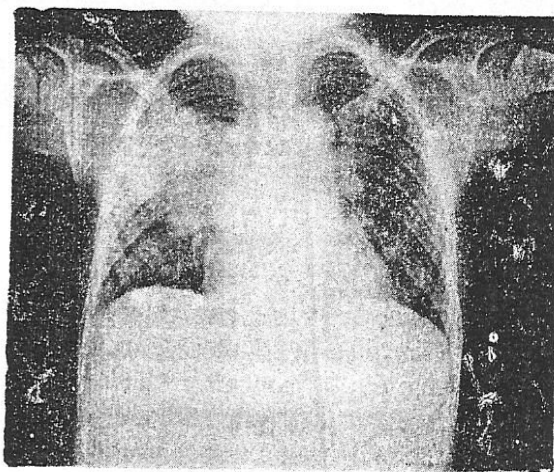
X-ray of the chest showing a paravertebral shadow due to a paraspinal abscess. Note also, tuberculous consolidation in the right upper lobe.
